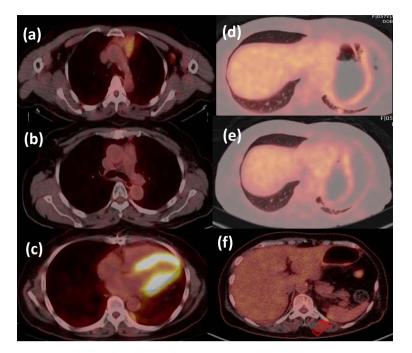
Transaxial F18-FDG PET/CT images of a 60-year old female with a hypermetabolic mass in the anterior mediastinum (SUV_{max} 5), consistent with Type B3 thymoma. (b) Post-total thymectomy with adjuvant radiation therapy scan showed interval resolution of FDG uptake in the surgical site. However, thymoma clinically recurred with metastases to the pleura (c), lung (d), and spleen (f) with low-grade FDG uptake. Post-resection of left lower lung hypermetabolic lesion (e).
